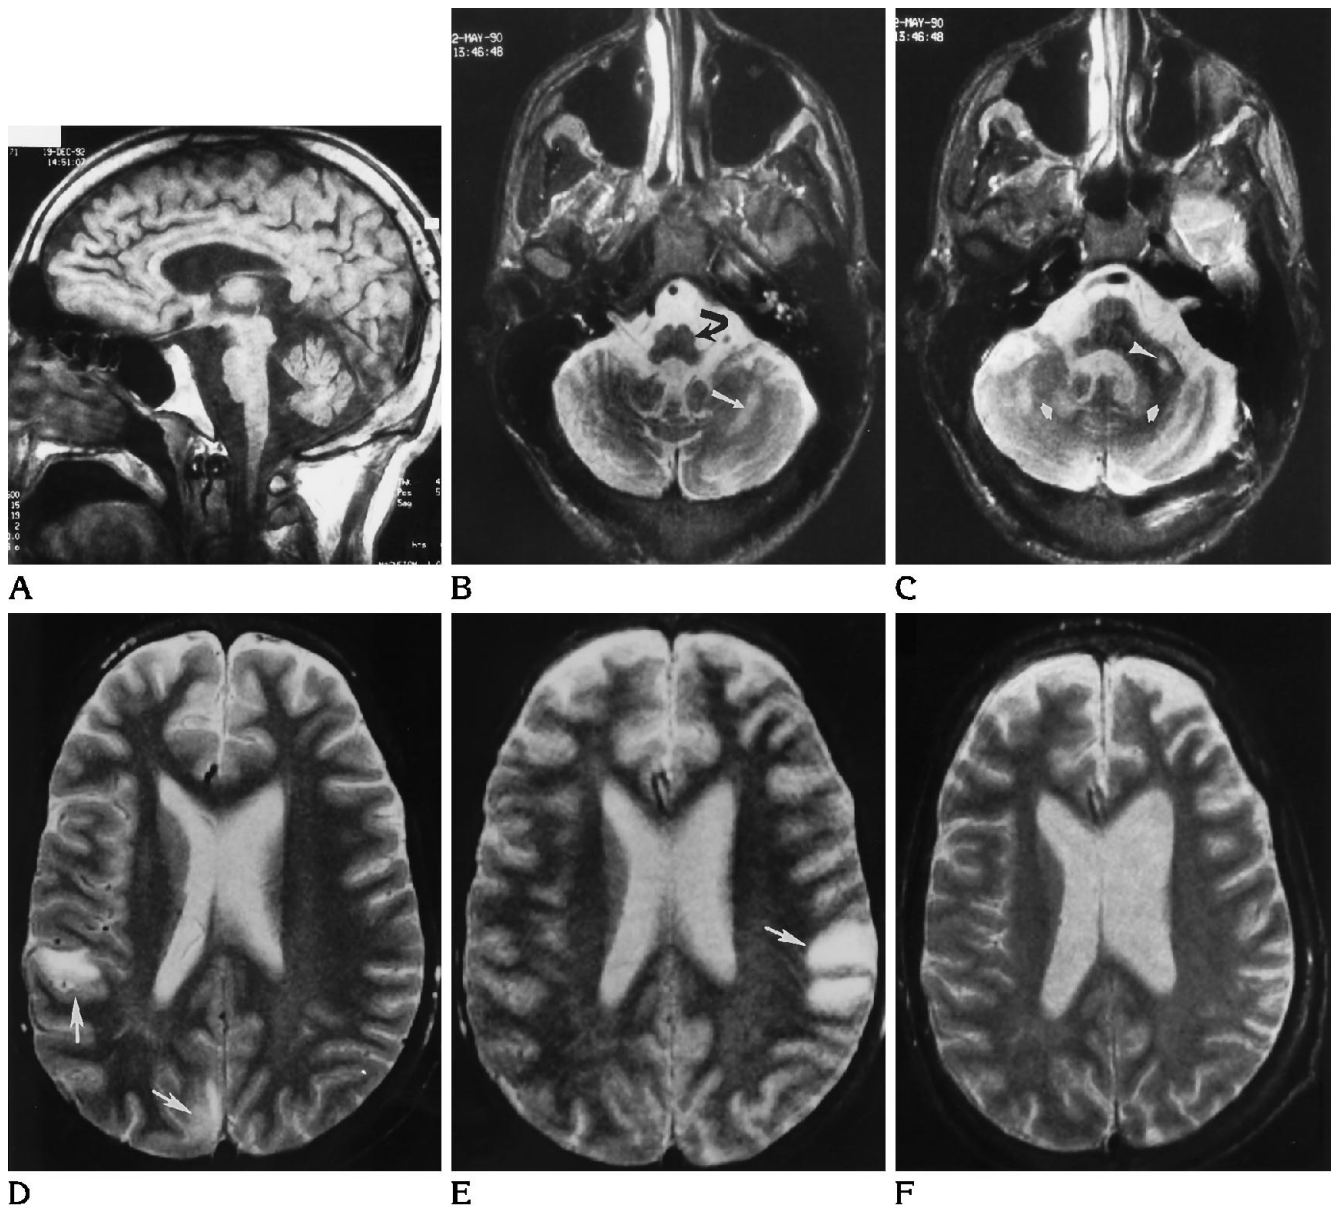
A, T1-weighted sagittal image (500/15/1) of patient 6. Atrophy of the brain stem is evident, but the shape of the belly of the pons is still preserved. There is marked widening of all posterior fossa cerebrospinal fluid spaces.
